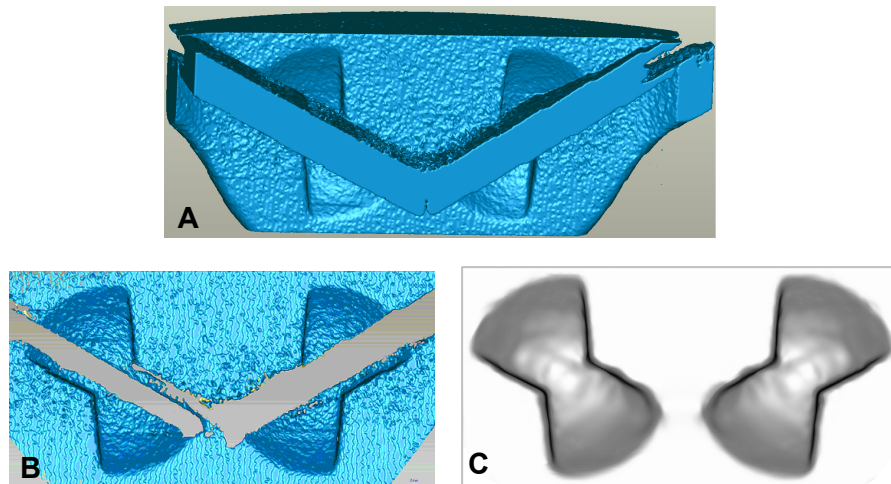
Reconstruction of the hinge recess of a 23 mm SJM Regent valve scanned with 18 μm resolution. A: Original micro Computed Tomography scan, B: Hinge region extracted from the original scan. Loss of data is clearly visible and can be attributed to the presence of the valve leaflets. C: Reconstructed hinge recess.
